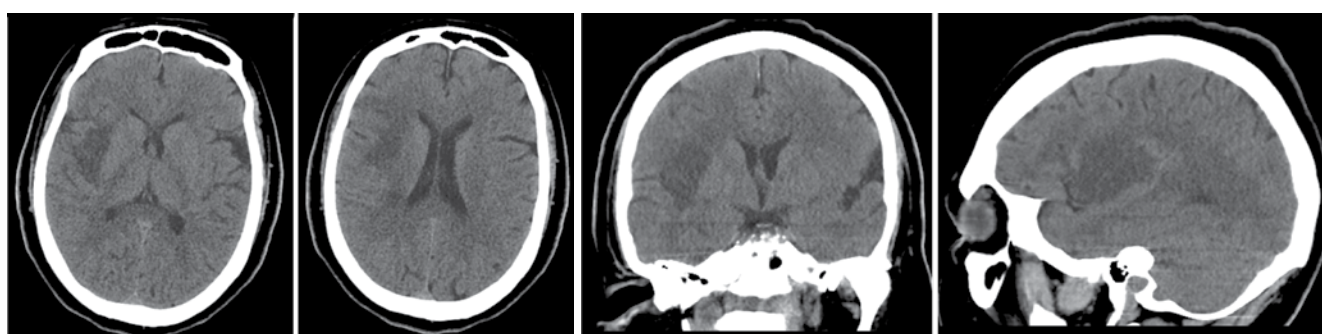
CT scan of the brain of patient F. 7 days after admission to the RSC
